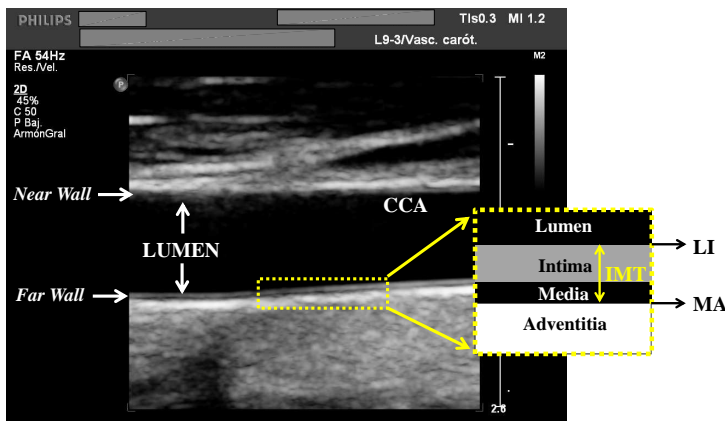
Longitudinal view of CCA in an ultrasound B-scan image and scheme of the carotid interfaces for IMT measurement.
